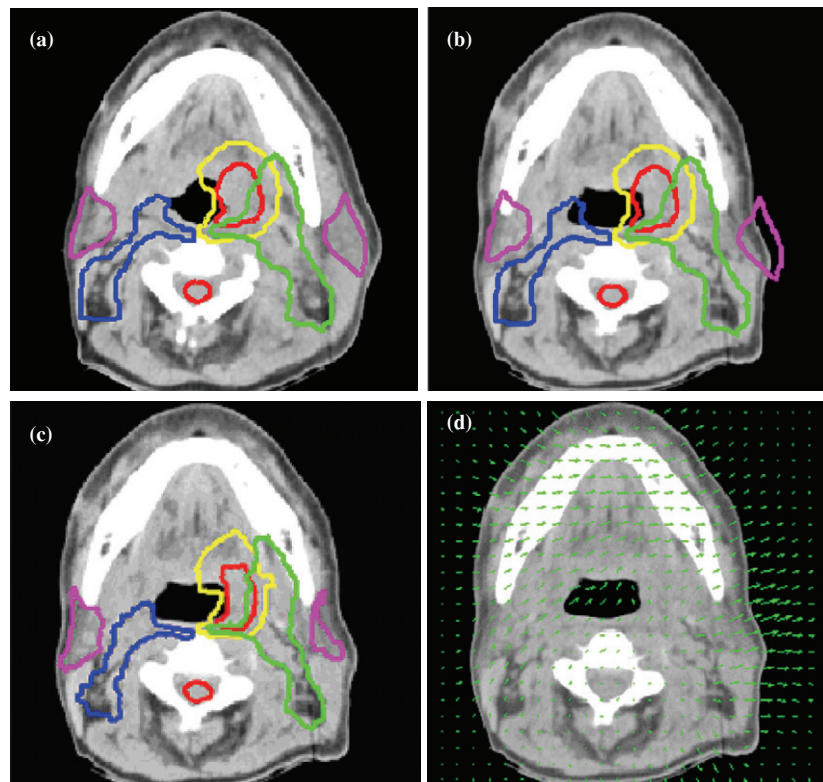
Autocontouring on head-and-neck images. (a) One slice of the planning CT with physician-drawn contour overlaid. (b) Corresponding slice on daily CT with planning contours directly overlaid. (c) Daily CT with deformed planning contours obtained by deformable registration algorithm. (d) Daily CT with displacement overlaid (scaled).
